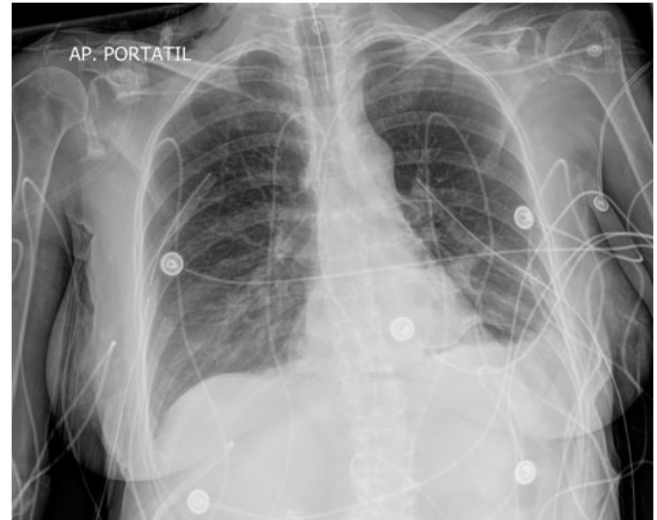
Anteroposterior chest x-ray with bilateral endopleural tube, with persistent image of left pleural effusion.
